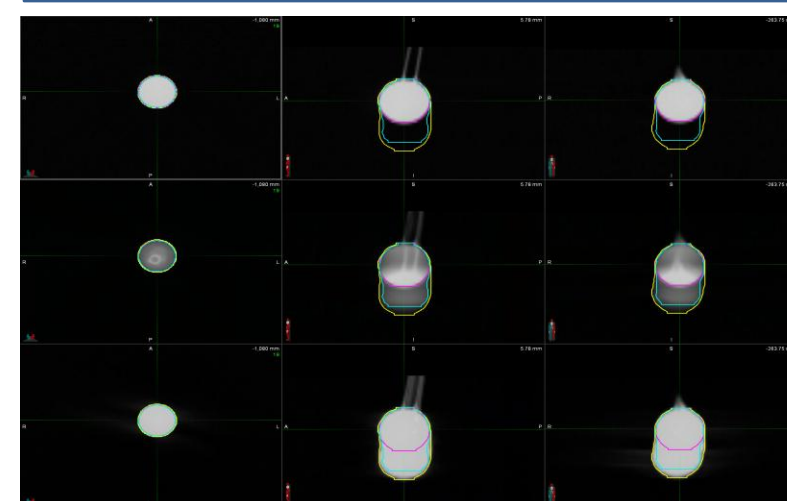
50% phase, AIP, and MIP 4D-CT images of a 30-mm nylon sphere. AIP and MIP demonstrate apparent motion-envelope broadening compared with the 50% phase image.
